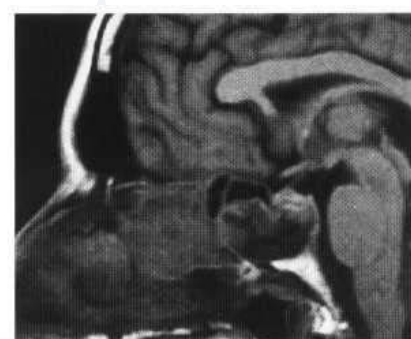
(A) Coronal CT scan showing diffuse and nodular calcification in the fungal mass in the sphenoid sinus. (B, C) Axial T₂ and proton density MRI scans demonstrate signal void from the fungal mass. (D) Sagittal T₁-weighted scan shows intermediate signal intensity material within the sphenoid sinus.
